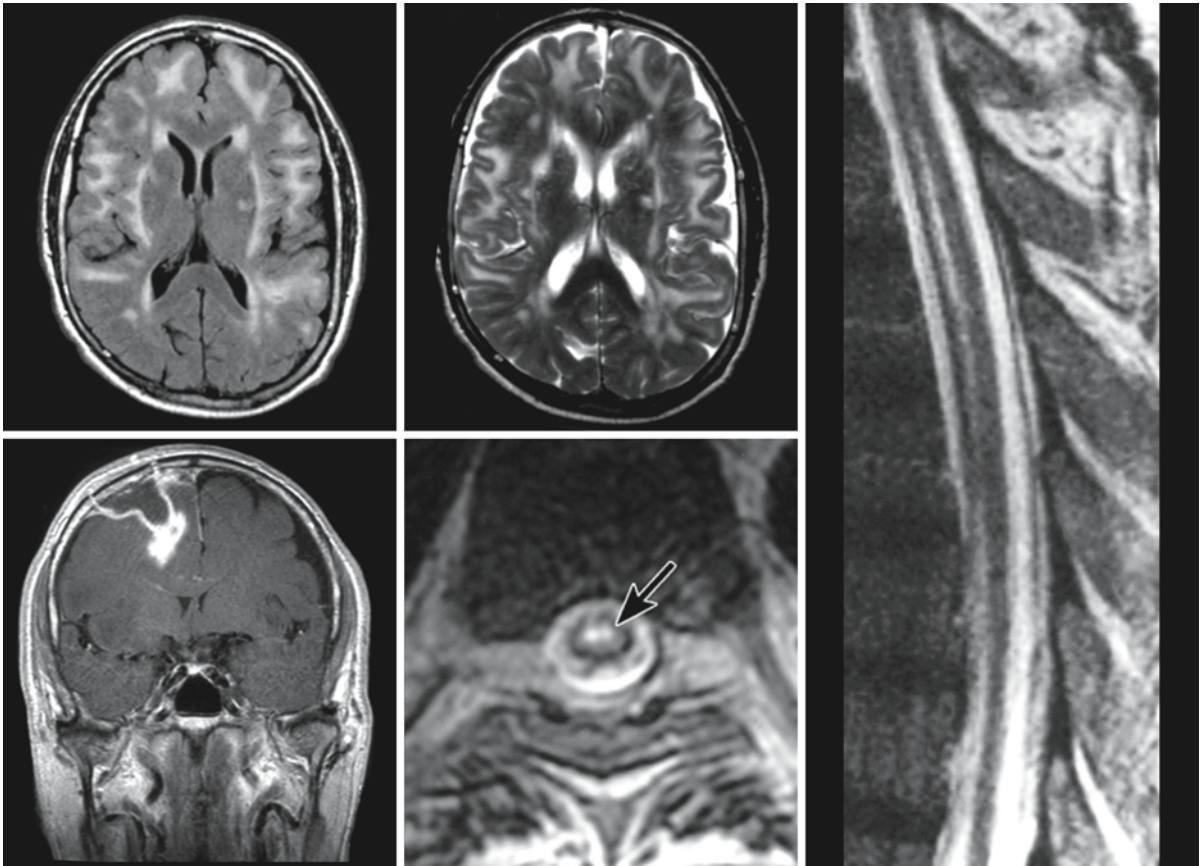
Brucellosis in a 65-year-old patient with both cerebral and spinal abnormalities. The two upper images on the left, FLAIR and T₂-weighted respectively, show symmetrical involvement of most of the cerebral white matter, most prominently of the arcuate fibers and the external capsule. The lower left image, T₁-weighted with contrast, shows meningeal involvement and abscess formation with a cyst-like component
